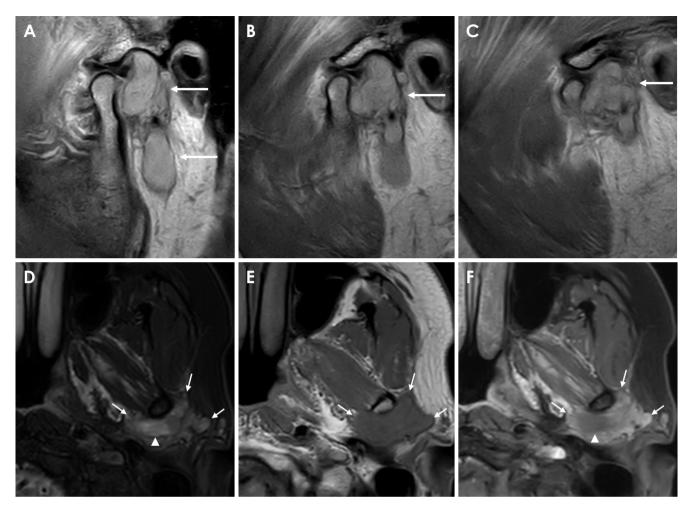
Magnetic resonance imaging taken 7 months after the initial visit. Serial images of sagittal gadolinium-enhanced T1 weighted images (A-C) show a lesion extending from the retrodiscal area down to the parotid parenchyma. An axial fat-suppressed T2 weighted image (D) shows a hyperintense T2 signal lesion (arrows) with a local increase in signal intensity (arrowhead). An axial T1 weighted image (E) shows an isointense-signal lesion (arrows). An axial fat-suppressed gadolinium-enhanced T1 weighted image (F) shows a heterogeneously enhancing lesion with a medial non-enhancing area (arrowhead).
